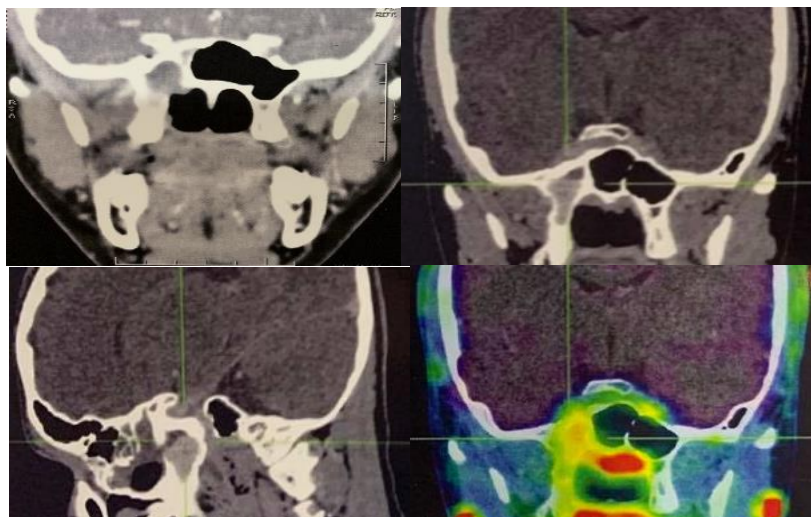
Post-operative PET/CT image of a case with JNA showing recurrence of the tumor in the right pterygoid base.
